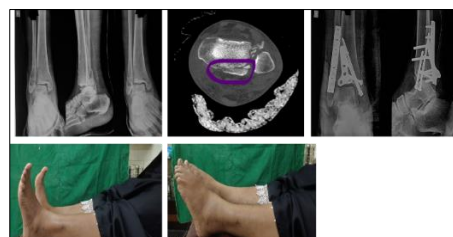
(A) Pre-operative radiograph of 44year old female, showing Denis weber type-B tri-malleolar fracture of right ankle. (B) Post-operative radiograph showing anatomic reduction and stable fixation using various implants.
